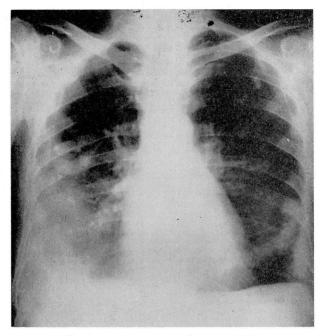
Roentgenogram of chest in 1949.
